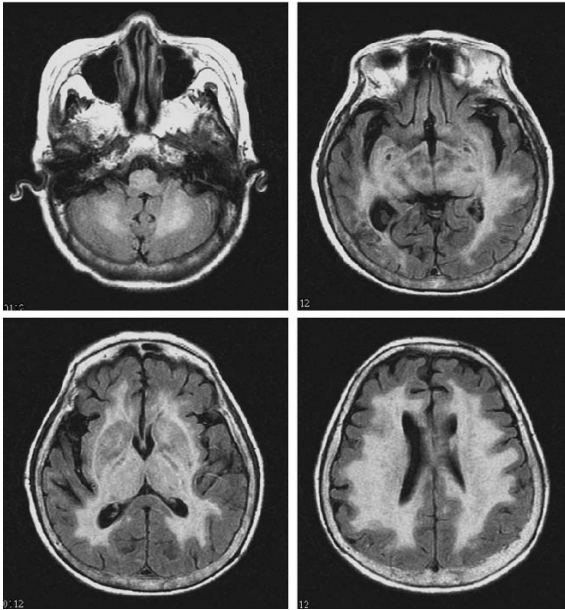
A FLAIR MRI on admission shows extensive edema in the hemisphere white matters, brainstem, thalamus, basal ganglia, and cerebellum.
